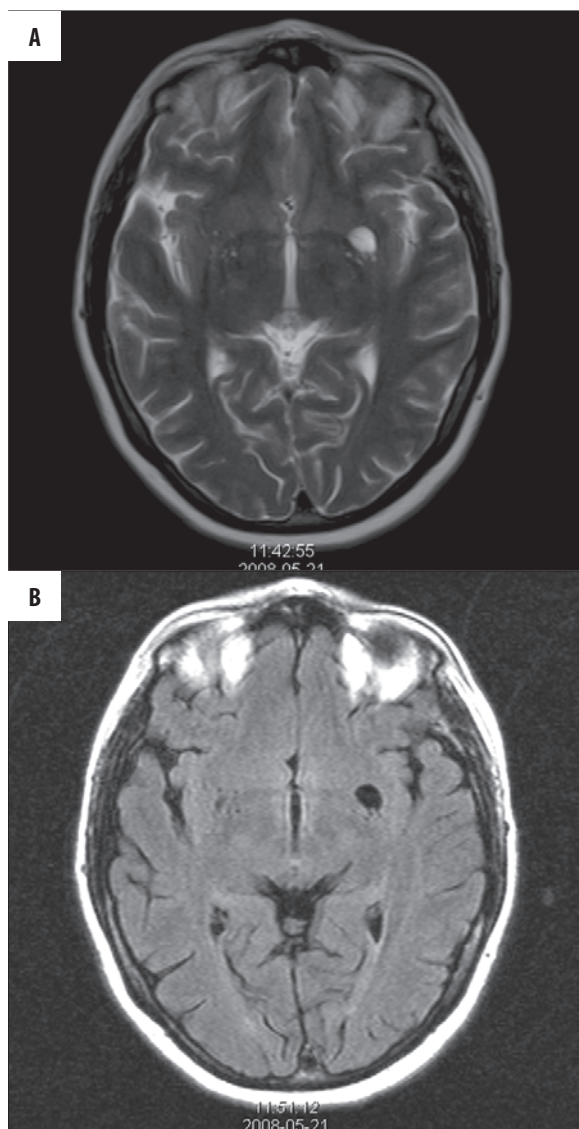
Multiple normal and single dilated VRS in the insular region in T2-weighted image (A) and in FLAIR sequence (B).
